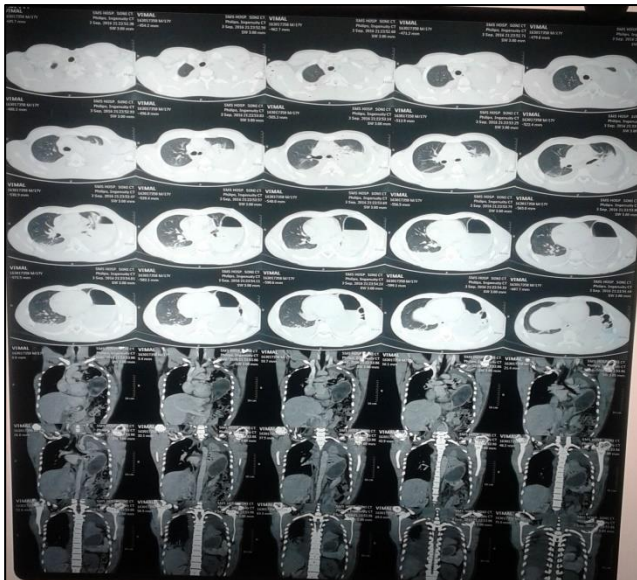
CT-scan of thorax showing collapsed lung and herniation of abdominal contents into thoracic cavity.
